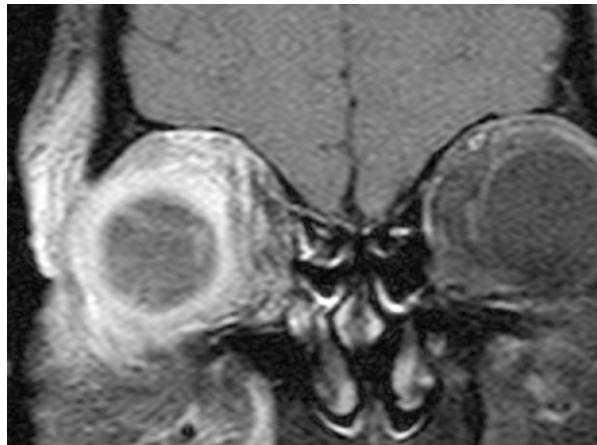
Coronal MRI scan showing orbital cellulitis associated with panophthalmitis of the right eye. Note the loculations of the opacified posterior segment of the right globe as well as thickening of the sclera
